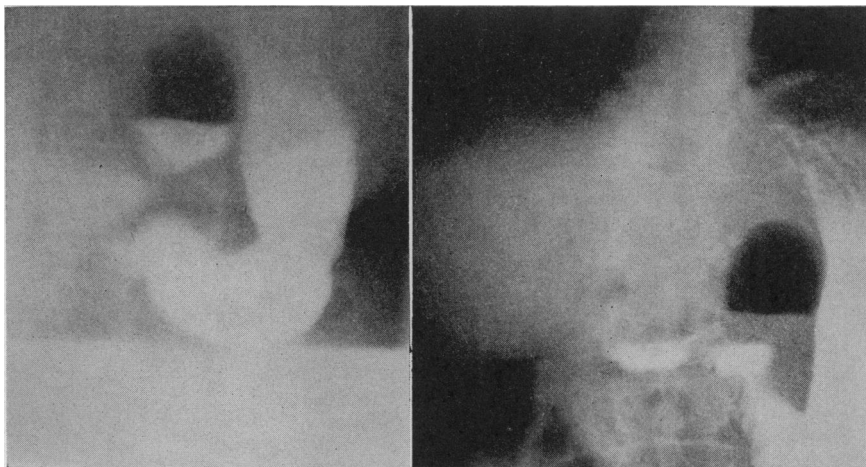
(Case 2).—Diverticulum of the fourth part of the duodenum, associated with a carcinomatous ulcer of the posterior wall of the stomach. The diverticulum had all of the roentgenographic characteristics of an accessory pocket due to perforated ulcer. The fluid level remained unchanged with change in posture of the patient.
